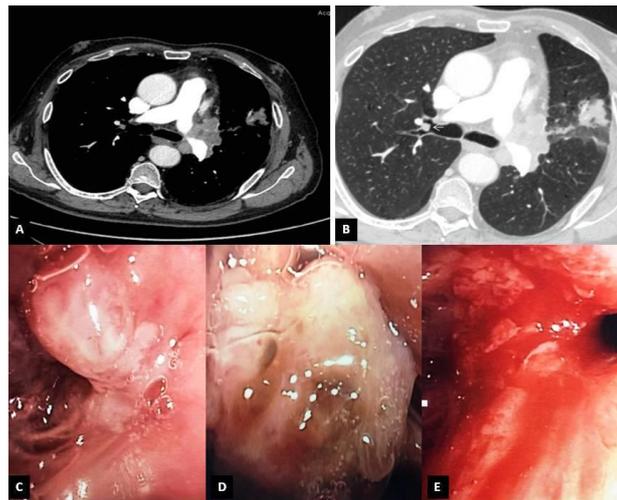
Contrast-enhanced Chest CT scan shows hilar tumor mass obstructing left upper lobe bronchus (A) and incidental small lesion in the upper right lobe (arrow in B). Bronchoscopic image showing left upper bronchial stenosis caused by malignant bronchial wall compression and infiltration (C). Bronchoscopic image showing soft polypoid neoplastic vegetation partially occluding upper right lobe (D). Complete removal of endobronchial vegetation with bronchial biopsy (E).
